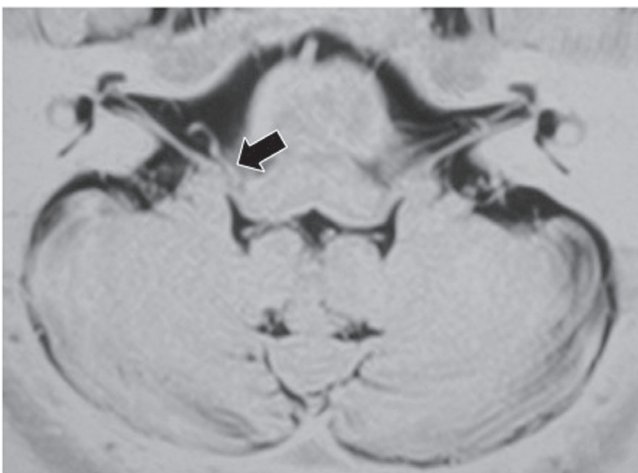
Preoperative magnetic resonance image from a patient with right hemifacial spasm. *Arrow* indicates the posterior inferior cerebellar artery that is compressing the root exit zone of the facial nerve.
